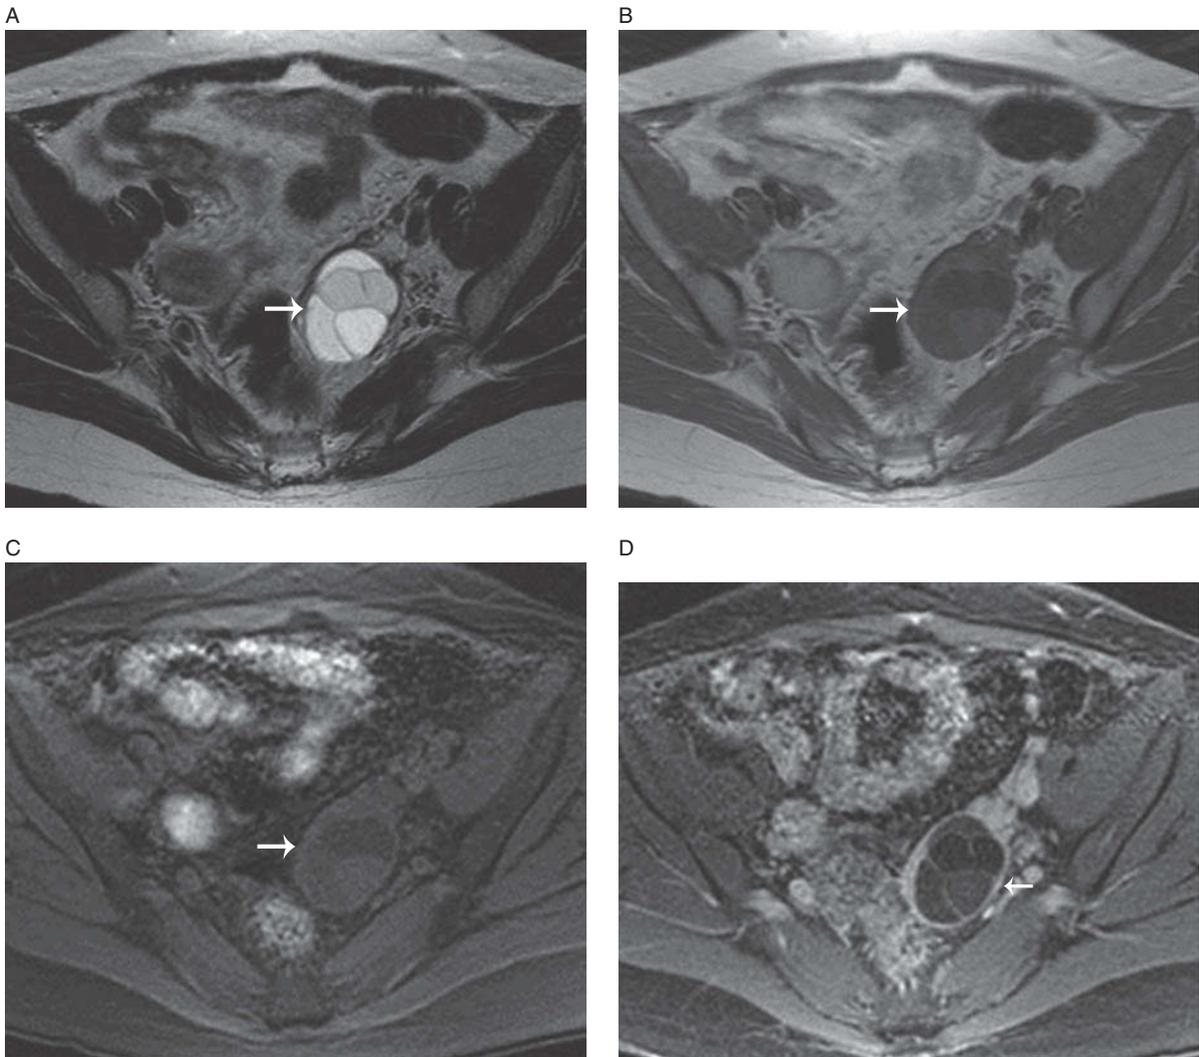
Mucinous cystadenoma in a 46-year-old female. Axial T2-weighted image (A) demonstrates a variable high and intermediate T2 signal intensity lesion in the left ovary (arrow). This lesion also has corresponding variable low and intermediate signal intensity on the corresponding axial T1-weighted images without (B) and with (C) fat saturation (arrow) due to mucinous contents. The post-contrast axial T1-weighted image with fat saturation (D) demonstrates enhancement of thin internal septations (arrow).
